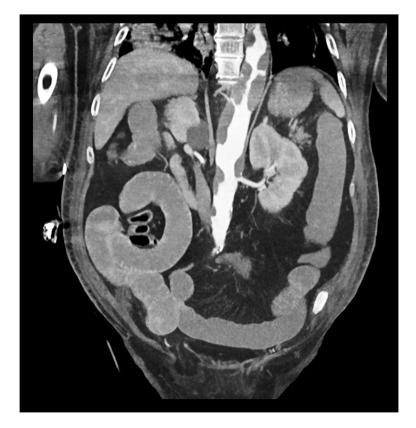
Fatal aortic thrombosis in COVID-19 patient. Arterial-TDM showing extended intra-luminal aortic thrombi in a patient suffering from COVID-19. A 74 years old patient was admitted in ICU for respiratory failure. Nasal swab confirmed the suspected COVID-19. Doppler ultrasound revealed no deep venous thrombosis despite D-dimers >20000UI/L. The patient received prophylactic enoxaparin (4000UI/12 h). On the 6th day, the patient presented lower *limb* ischemia and abdominal occlusion syndrome. Subsequent Arterial-TDM revealed *de novo* multifocal and circumferential aortic thrombi of suprarenal and subrenal localization, with up to 50% occlusion on the infra-renal portion. There were no associated deep vein thrombosis nor pulmonary embolism.
